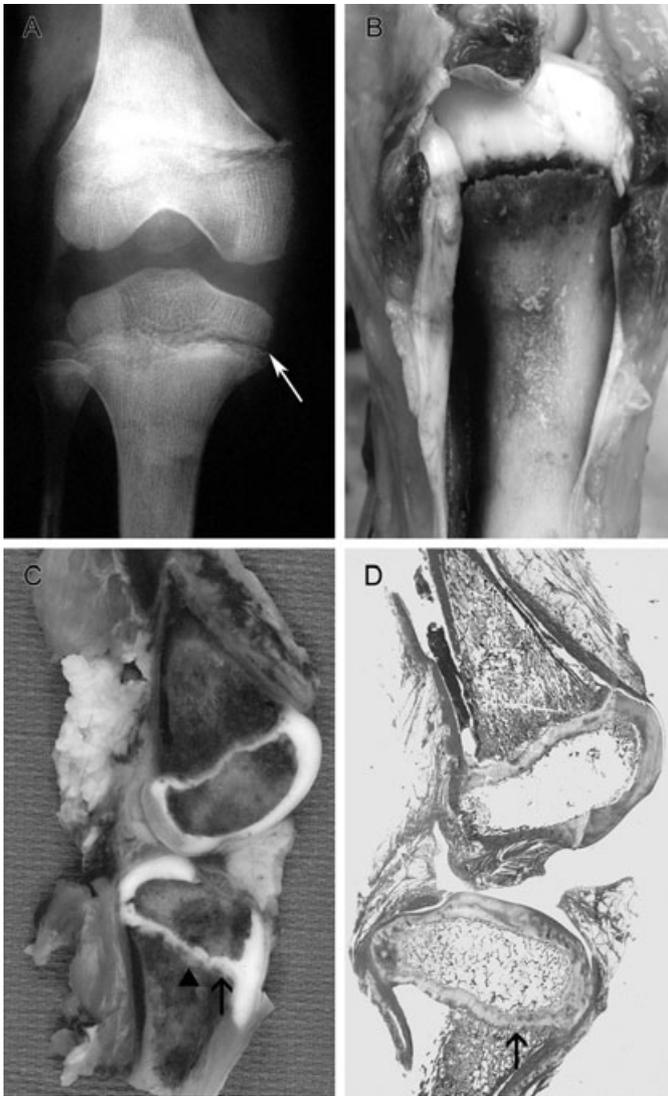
Right knee: (A) Postmortem radiograph with lesion interpreted as metaphyseal fracture of tibia (arrow). (B) Tibia in situ following layered dissection of knee joint demonstrating the epiphyseal separation under flexural pressure. (C and D) Whole mount of right knee joint showing a fine subepiphyseal tibial fracture line (C and D; arrows) and new bone and cartilage formation (C; arrowhead).
